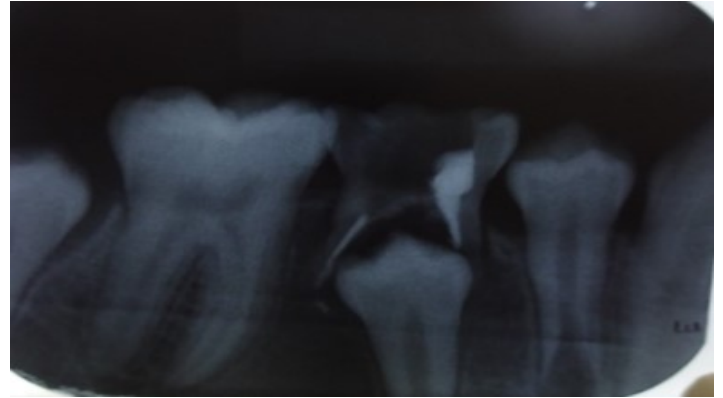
Preoperative panoramic radiograph showing unilocular radiolucency in left side of jaw
